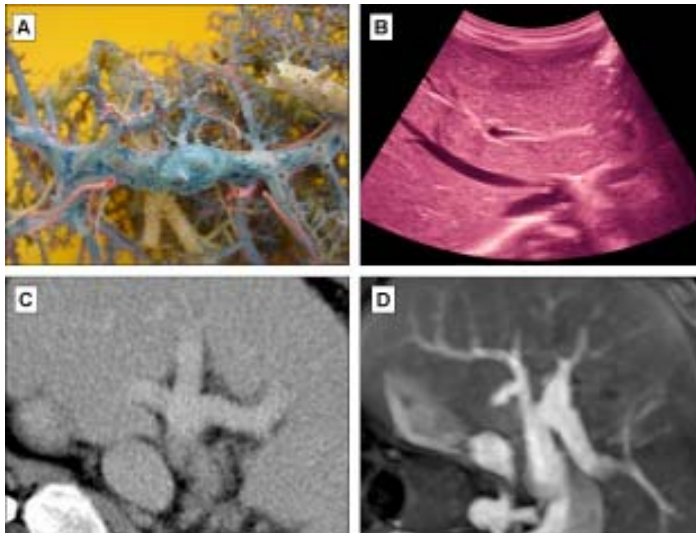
The methods of investigation of the divergence part of hepatic portal vein. A - The piece of corrosion cast; B - ultrasound image; C - MDCT angiography images; D - MR - angiography images. [Color figure can be viewed in the online issue, which is available at www.revmaterialeplactice.ro]
